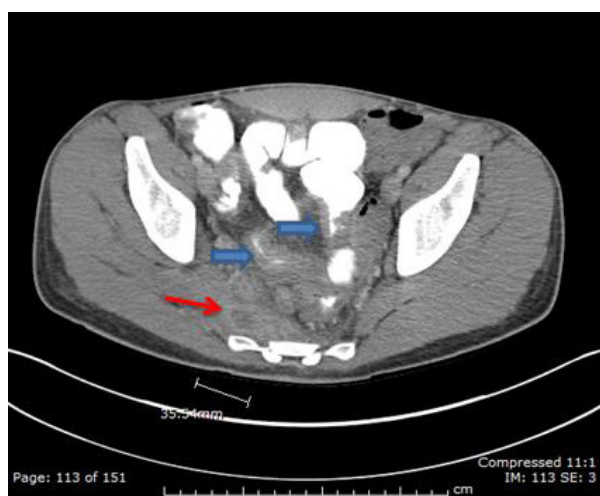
Axial computed tomography of the pelvis with oral and intravenous contrast material, at the level of the greater sciatic foramen, demonstrating a sinus tract extending to the right piriformis (red arrow), originating from a segment of the distal ileum (not shown). Segmental, transmural distal ileal wall thickening is also shown (blue arrows). Patient also has multiple ileocolic fistulae (not shown).
